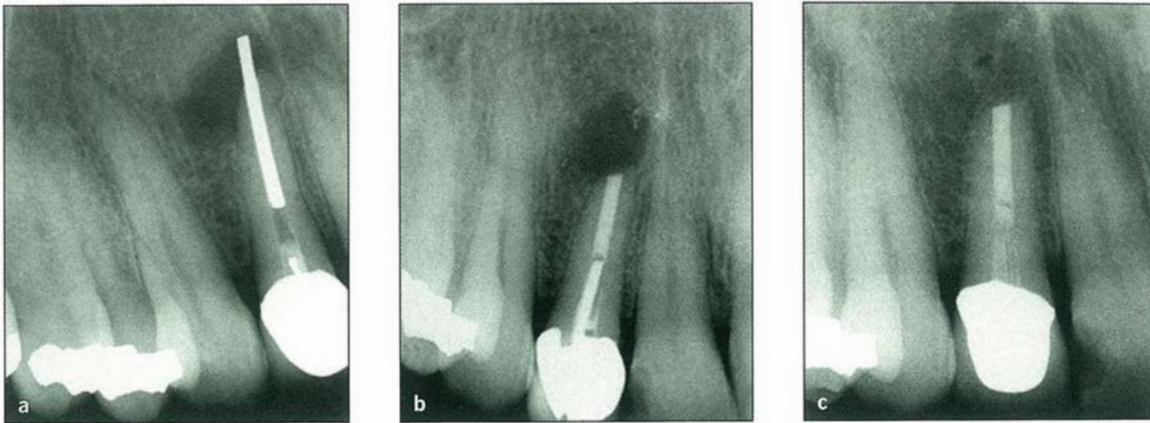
(a) Periapical radiograph showing an extensive radiolucency around the apex of the maxillary right incisor with an overextended silver point and an inadequate coronal seal. (b) The root canal was retreated nonsurgically and surgically using MTA as a root canal filling material. (c) Radiograph 3 years later showing complete resolution of the periapical lesion. (Courtesy of Dr Christopher Sechrist, Redlands, California.)
